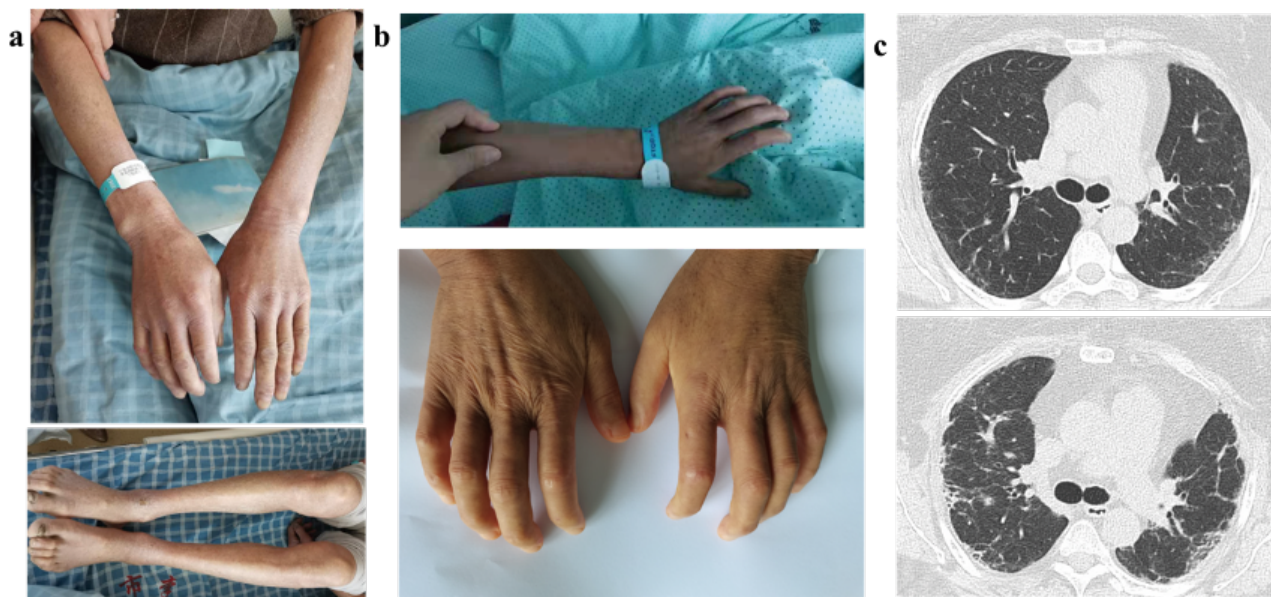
The clinical features of 3 RPSSc patients who developed tumour. (a) RPSSc patient with stomach cancer, who was dcSSc with rapid skin sclerosis onset progression and had cardiac involvement, gastrointestinal involvement and finger ulcers. (b) RPSSc patient with breast cancer, who was dcSSc with Raynaud's phenomenon and rapid skin sclerosis progression. The case was diagnosed with PBC and had joint involvement and trigeminal nerve involvement. (c) RPSSc patient with rectal cancer, who was lcSSc with Raynaud's phenomenon and ILD. The case was defined as RPSSc due to evidence of pulmonary fibrosis on high-resolution CT scan and a decline in FVC >15% during 6-month interval.
